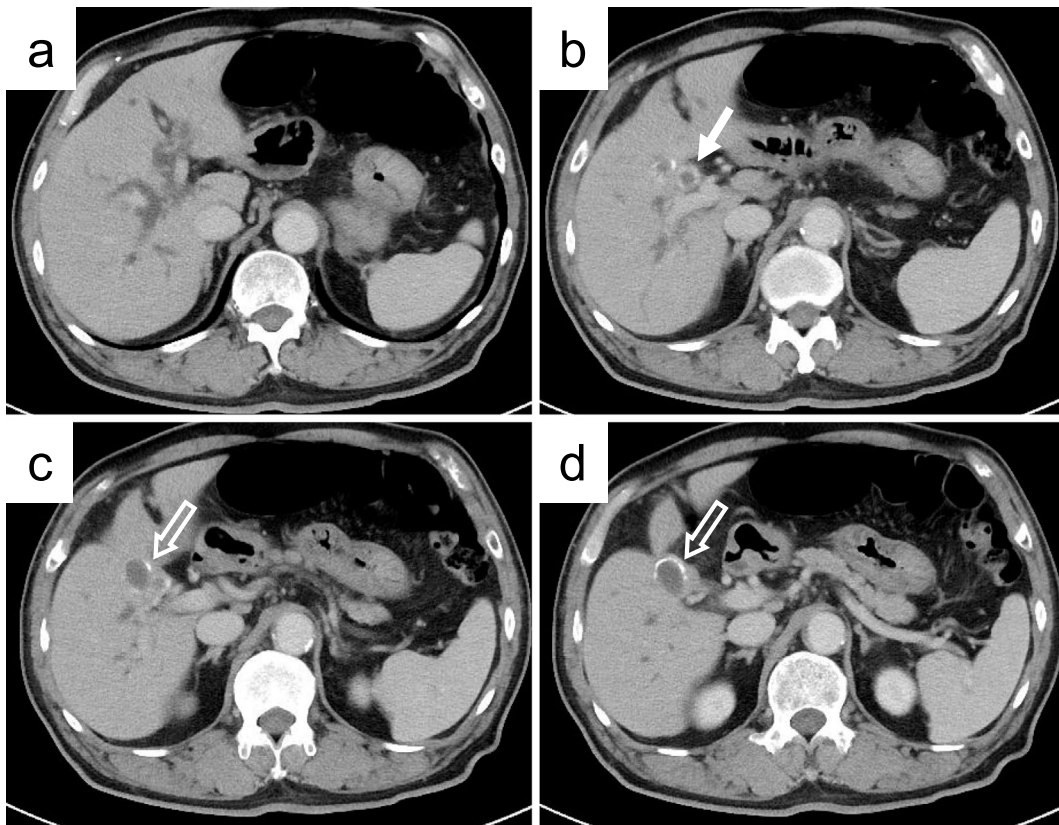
Contrast-enhanced computed tomography performed at admission, showing a stone at the left side in the common hepatic duct (closed arrow) and another stone at the right side in the same cavity (open arrow). The two stones were impacted in the eroded common hepatic duct, leading to dilatation of the intrahepatic bile ducts (a-d).
